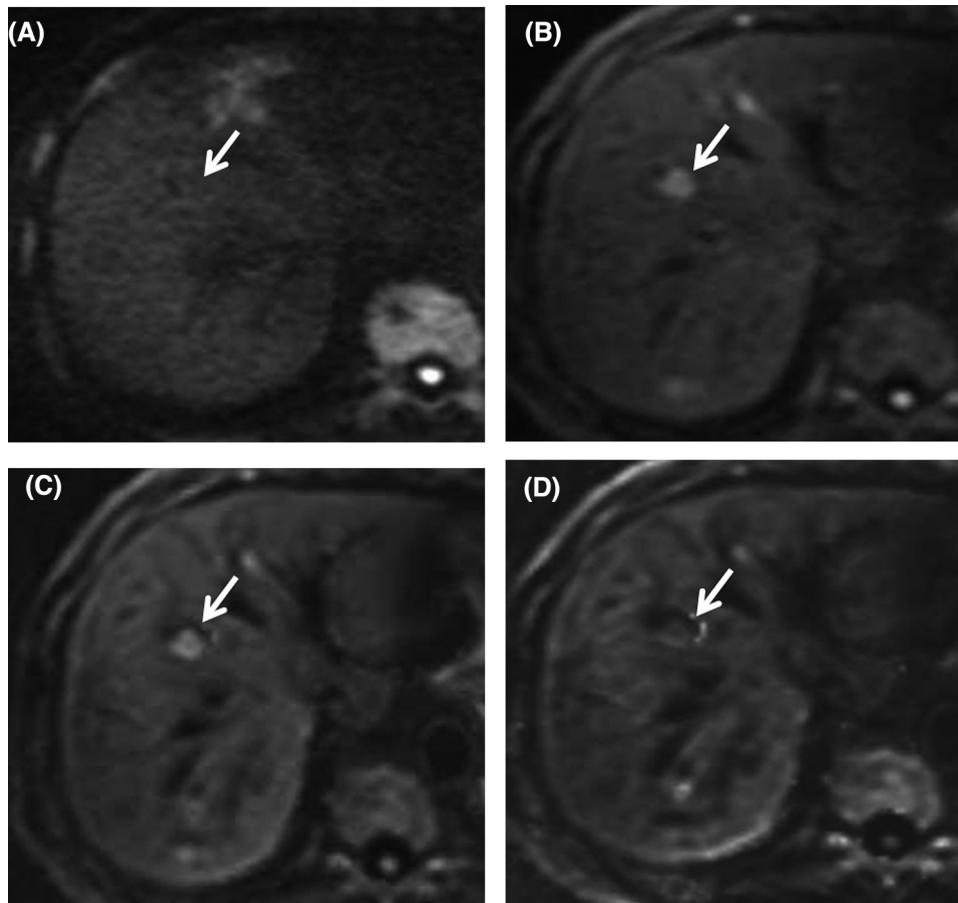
Hepatic cyst in an 80-year-old man. (A) o-1.5T-1000-, (B) o-3T-1000-, (C) c-1000-, (D) c-1500 DWIs. The cyst (arrow) was isointense on o1.5T-1000-, showed mild high signal intensity on o-3T-1000- and c-1000-, and was isointense on c-1500 DWI.
